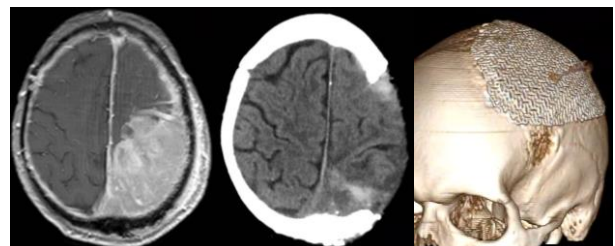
(left) Preoperative contrast-enhanced MRI demonstrating an intracranial mass with intraosseous extension; (center) postoperative CT scan following tumor ablation and craniectomy; and (right) 3D reconstruction of the cranial defect with a contoured titanium mesh implant.
